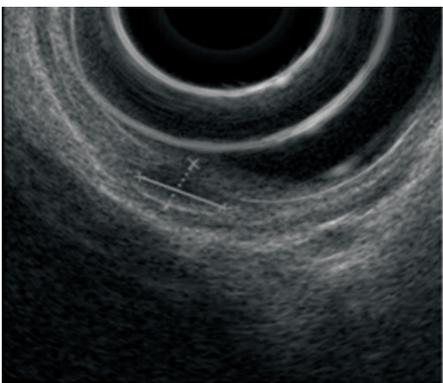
A hypoechoic tumor (4.2 mm × 2.6 mm) in the muscularis mucosae covered by intraepithelial layer by endoscopic ultrasonography.
